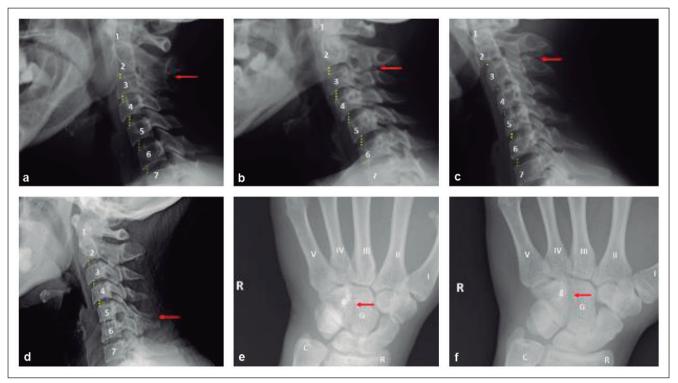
Vertebral cervical radiographs showed the intervertebral space is significantly narrow and spinous process fusion between:C2-3 patient I-5 (a), II-10 (b) and II-14 (c), respectively; C5-6 patiente II-6 (d). X-ray of the carpometacarpal showed fusion between the capitate and hamate bone: The patiente II-10 (e) and II-14 (f), respectively. R, right; G, capitate; g, hamate.
